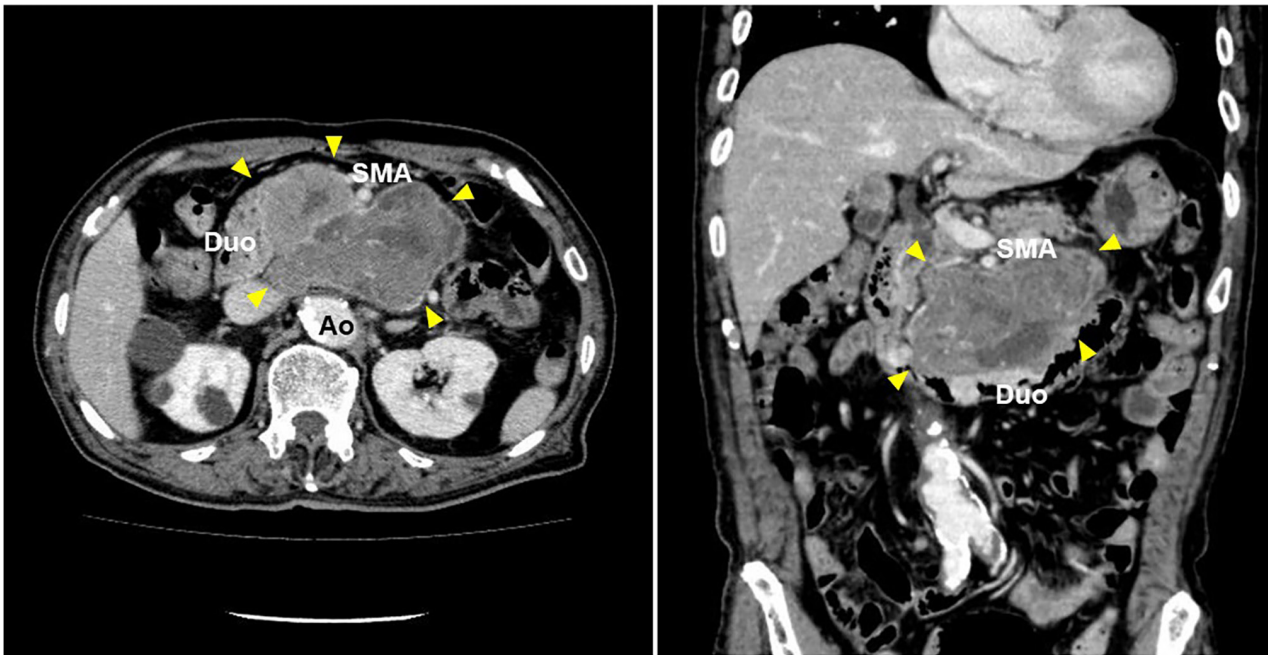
Abdominal contrast-enhanced computed tomography. Left, an axial slice; right, a coronal slice. The tumor was 11.7x8.7 cm in size and exhibited as an irregularly shaped mass with heterogenous enhancement (arrowheads). The tumor was encompassed by the Ao and the SMA and located in the retroperitoneum adjacent to the third portion of the Duo. Ao, abdominal aorta; Duo, duodenum; SMA, superior mesenteric artery.
